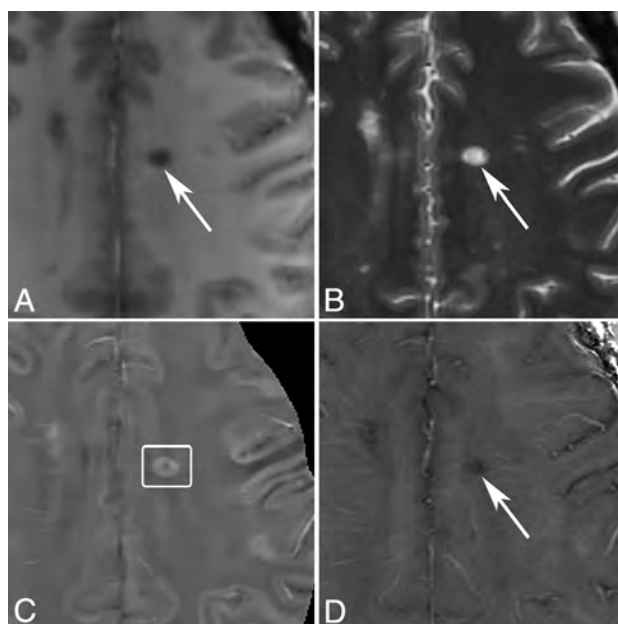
MR images of a nonenhancing lesion that is 1.2 years old in a 48-year-old woman with MS. A, T1WI + Gd. B, T2WI. C, QSM. D, R2*. One lesion appears hyperintense with a thick rim on QSM and hypointense on R2*.
